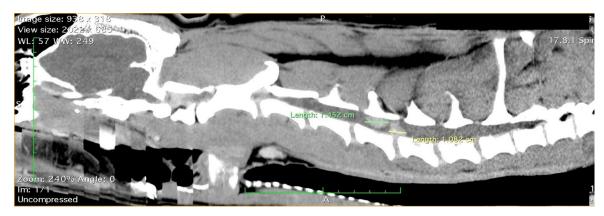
Sagittal CT image- structure with a neoformation character at the medullary level of the C5-C6 segment (green and yellow lines).
